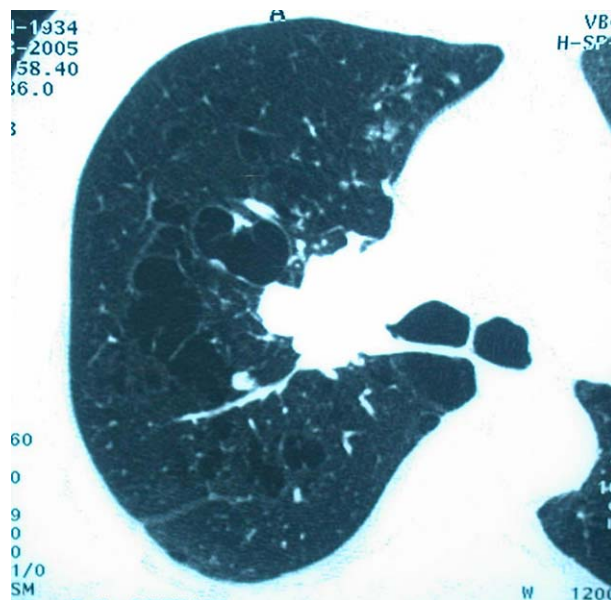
The chest CT revealed a parenchymal lesion, in the right hilar region which was obliterating the main bronchus.
